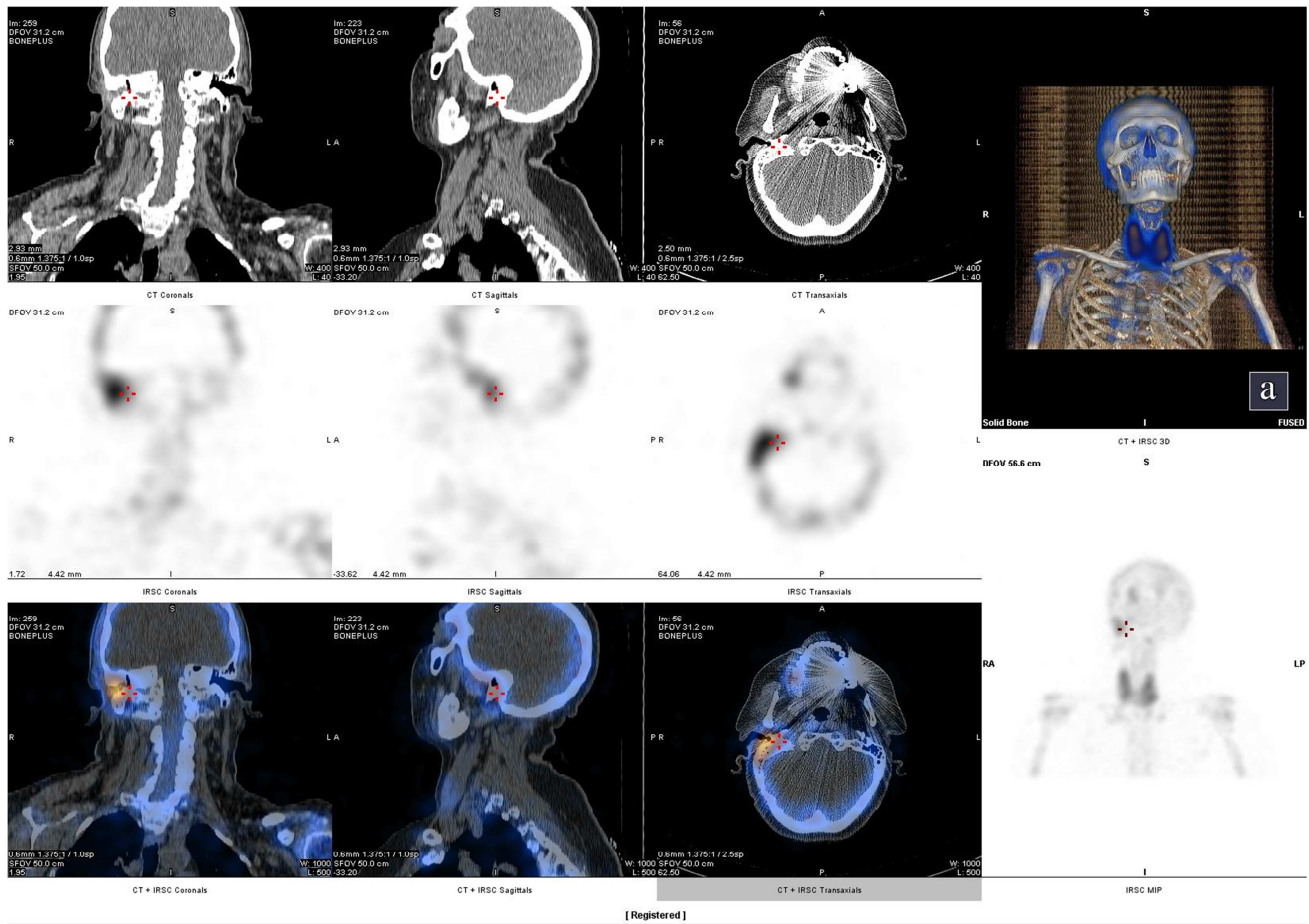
Showed SPECT-CT showing uptake in the squamous, tympanic and mastoid process. Along with it there is visualization of thyroid gland.
